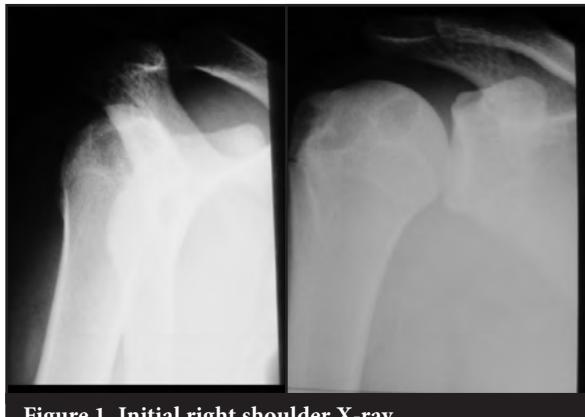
Initial right shoulder X-ray
